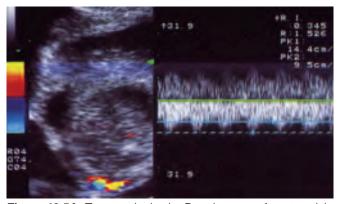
Transvaginal color Doppler scan of acute pelvic inflammatory disease. Note hyperechogenic tubal walls and low impedance blood flow signals (RI=0.35) obtained from tiny tubal arteries
